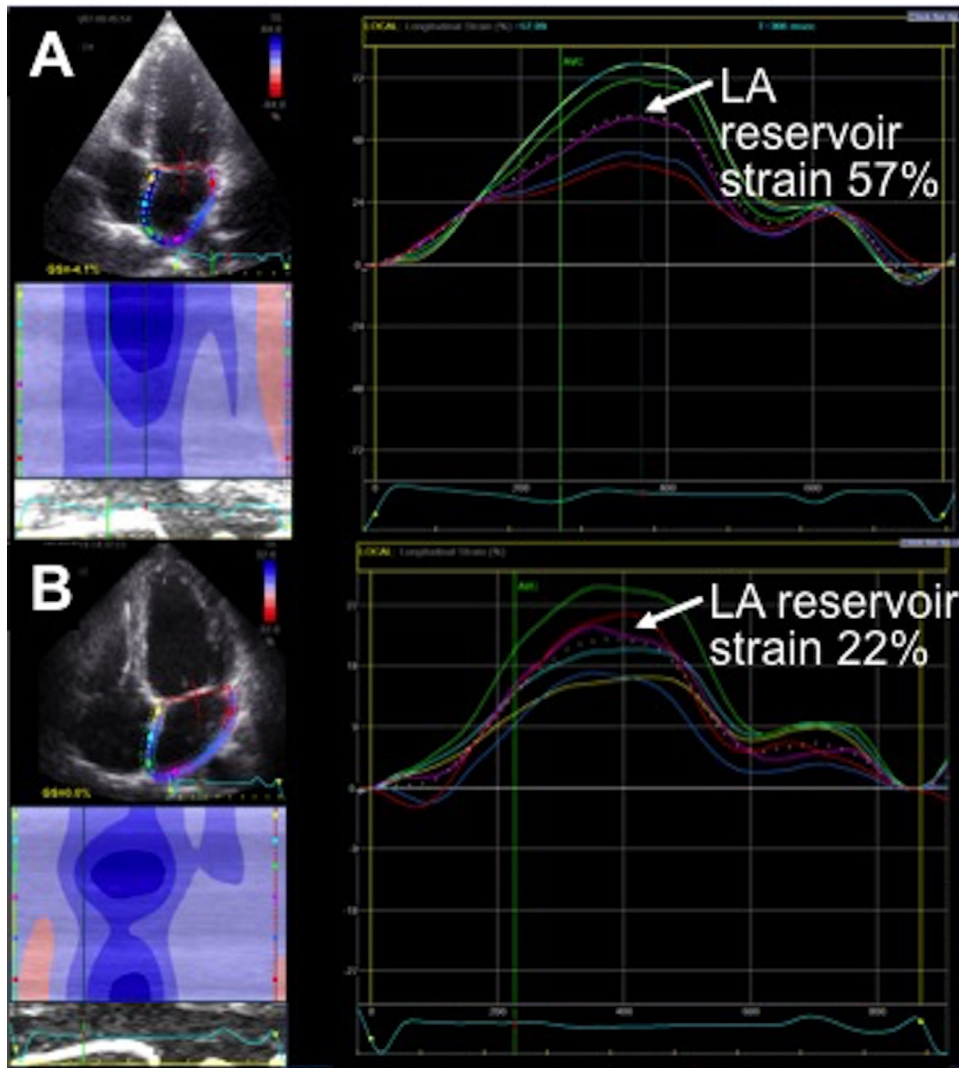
Example of measurement of LA reservoir strain in a patient with AF, and a control subject. The LA reservoir strain measurement was performed during sinus rhythm in both individuals. The LA endocardium is manually traced in the apical 4-chamber view, and region of thickness adjusted to the LA wall. LA reservoir strain is measured as the peak global longitudinal strain during ventricular systole (white dotted curve, arrow). Panel (A) demonstrates normal LA reservoir strain of 57% in a control individual, and panel (B) shows reduced LA reservoir strain of 22% in a patient with PAF.
